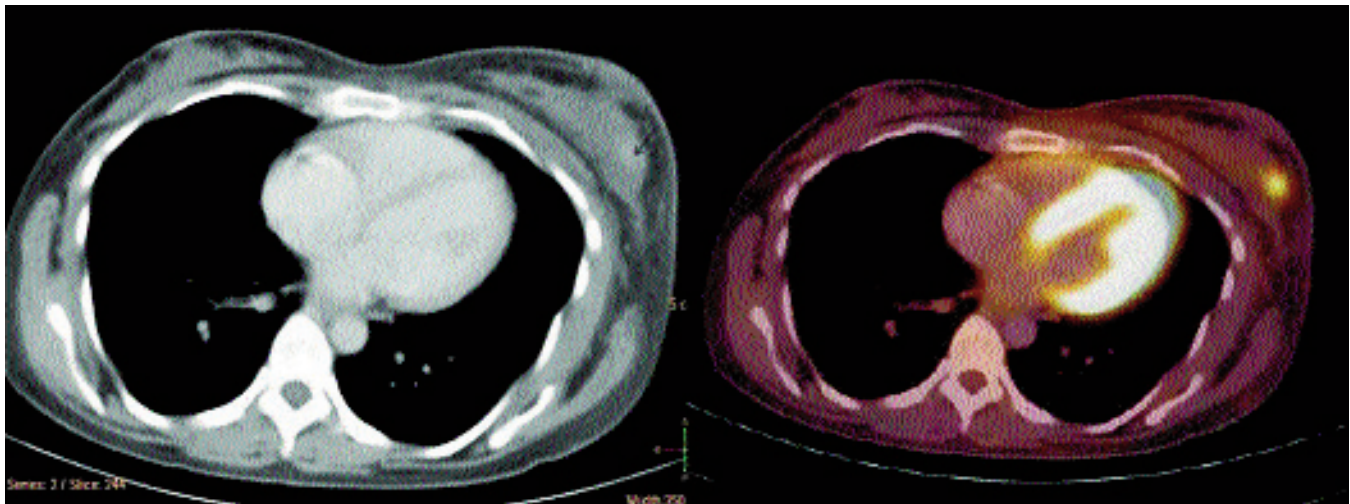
Comparison of disease stage between CT scan and FDG-PET scan.
